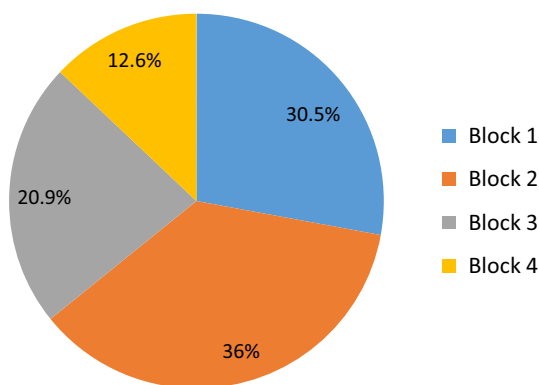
Direct costs from Brazilian intensive care units (ICUs). Data obtained from [45]. *Block 1* (30.5 %) = clinical support services: electrophysiology (0.1 %), lab tests (1 %), cultures (0.3 %), par-enteral and enteral nutrition (18.1 %), dialysis methods (3.4 %), respiratory physiotherapy (0.7 %), invasive and noninvasive ventilation (6.1 %), X-ray (0.8 %). *Block 2* (36.1 %) = consumables: intravenous or oral medications (including antibiotics) (32.8 %), colloids (0.3 %), albumin (2.6 %), fresh frozen fresh plasma (0.1 %), packed red blood cells (0.3 %). *Block 3* (20.9 %) = staff: standard monitoring (6 %), sample blood or other fluids collected (0.5 %), central venous catheter (5.3 %), pulmonary artery catheter (1.7 %), dialysis catheter (intravenous or peritoneal) (2.8 %), intracranial pressure monitoring (0.01 %), arterial catheter (0.8 %), clothes changes (1.7 %), caring for drainages (0.1 %), cardiopulmonary resuscitation (0.1 %), tracheotomy (0.6 %), laparotomy (0.3 %), neurosurgery (0.4 %), thoracotomy (0.2 %), other surgeries (0.1 %). *Block 4* (12.6 %) = hospital fees (12.6 %)
